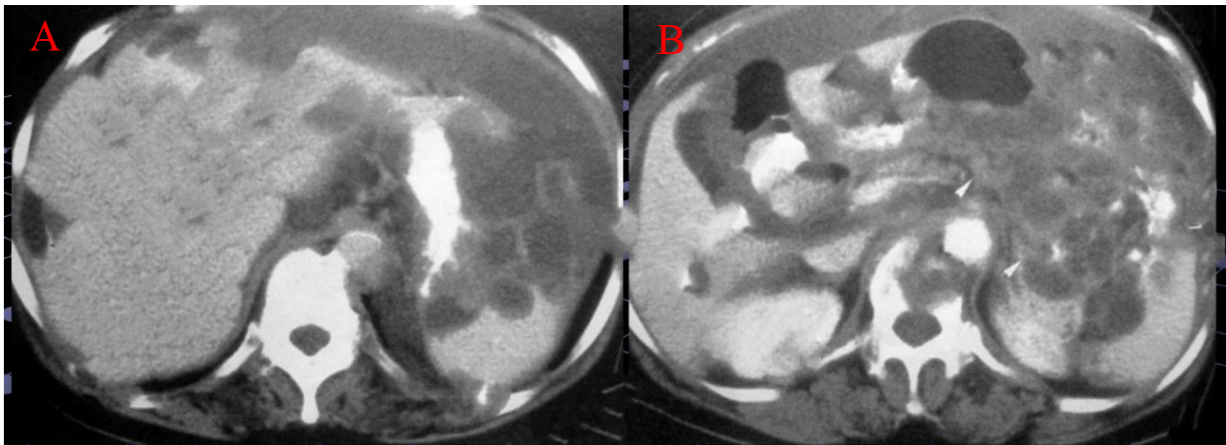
Imaging results of case 1. Red arrow indicates the location of the calcification. A, Enhanced CT image of the liver. B, Enhanced CT image of stomach and spleen.
